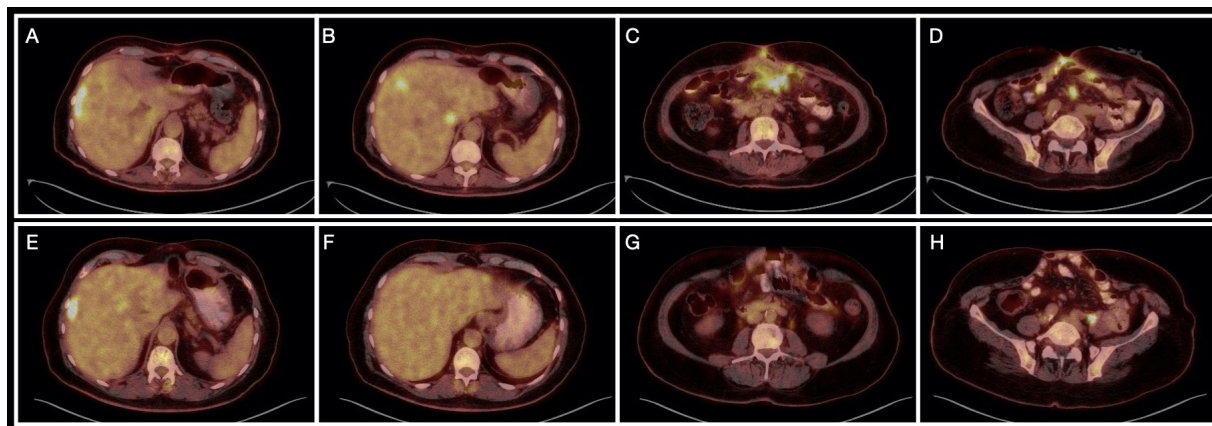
PET-CT scan images between two distinct periods of the patient’s management. Pictures A, B, C, and D, were taken from PET-CT scan done prior to starting chemotherapy. The scan showed pathological lesions in the liver, small bowel mesentery, and peritoneum. Pictures E, F, G, and H, were taken from PET-CT scans done after 18 cycles of FOLFIRI plus cetuximab, before CRS/HIPEC. The images showed the degree of response to the chemotherapy
